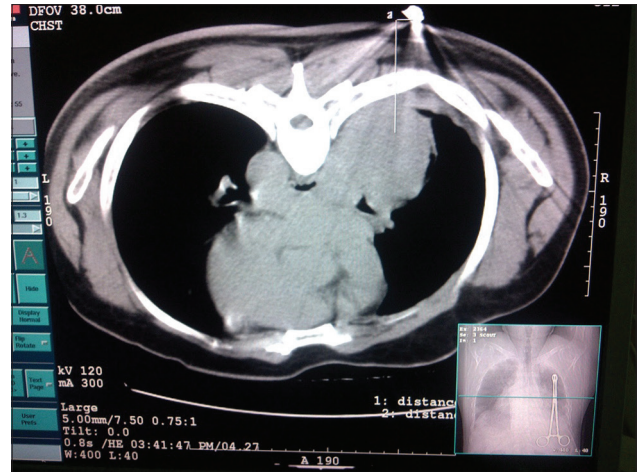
Localization of the lesion by computed tomography scan ruler indicated by the white vertical line in the lesion on the right and a horizontal limb pointing to the metallic object
